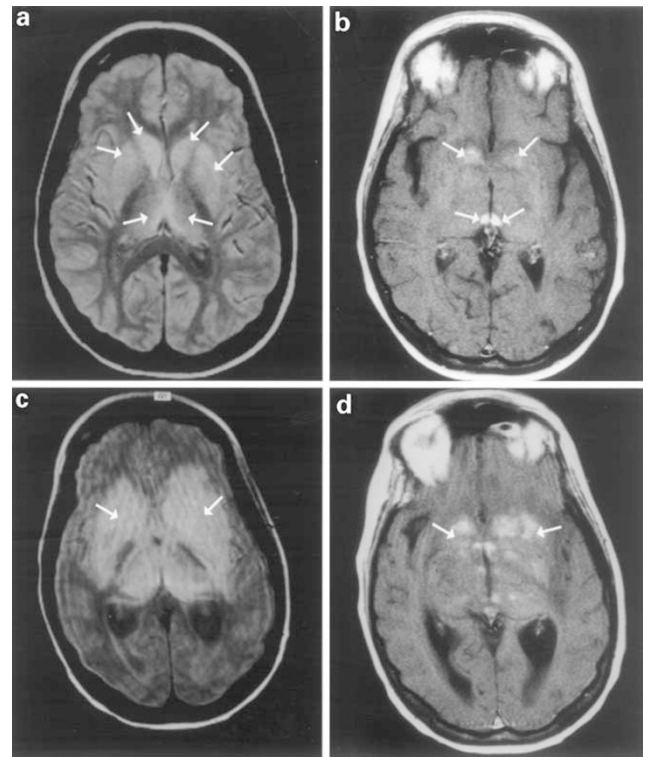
(a) Proton-density-weighted MRI scan demonstrates abnormal increased signal intensity within the caudate nuclei, lentiform nuclei and medial thalami. (b) T1-weighted MRI scan after the administration of gadolinium demonstrates areas of contrast enhancement within the basal ganglia and intense enhancement within the habenular region. (c) Repeat proton-density-weighted MRI scan and (d) T1-weighted MRI scan demonstrate dramatic progressive, confluent abnormal signal intensity within the deep gray matter nuclei and relative lack of involvement of the hemispheric white matter. Administration of gadolinium demonstrates extensive enhancement within the deep gray matter nuclei.
